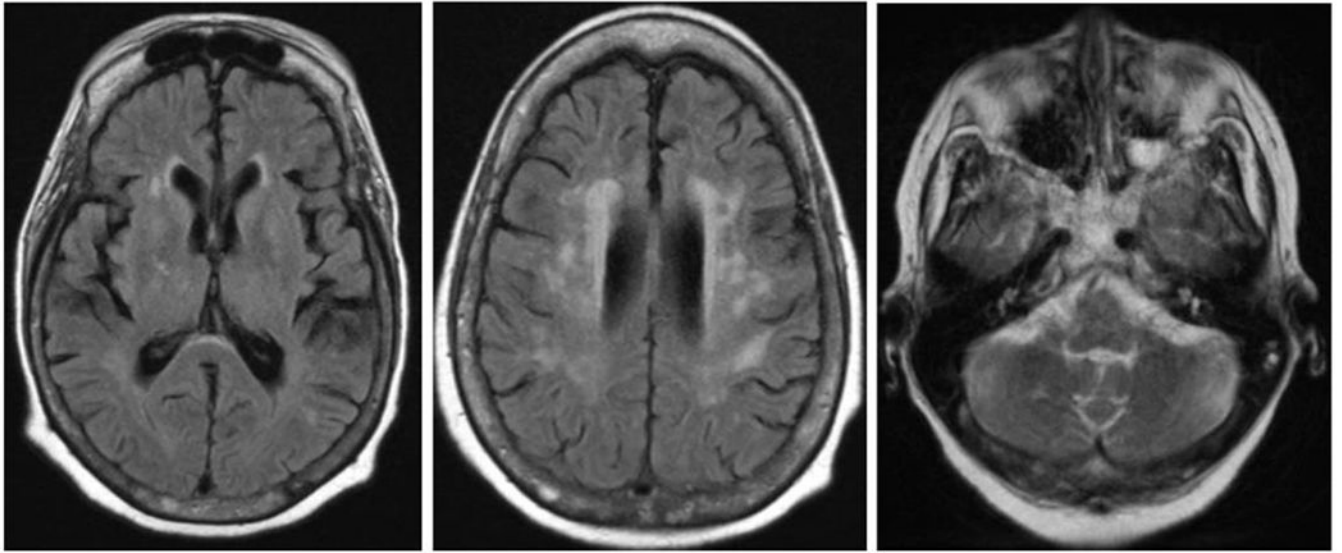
Index kidney recipient MRI brain with and without contrast two months post-transplantation
